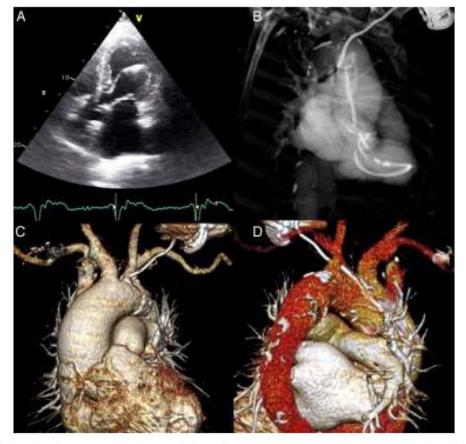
(A) Transthoracic echocardiography, apical 4-chamber view, showing the pacing lead passing through the aortic valve to insert in the left ventricular lateral wall; (B) thoracic computed tomography angiography (CTA), maximum intensity projection image, showing the entire trajectory of the pacing lead through the aneurysmal ascending aorta, aortic valve and left ventricle; (C) volume-rendered thoracic CTA showing pacing lead perforating the atheromatous aortic arch; (D) volume-rendered thoracic CTA showing perforation site between the left common carotid artery and the brachiocephalic trunk.
